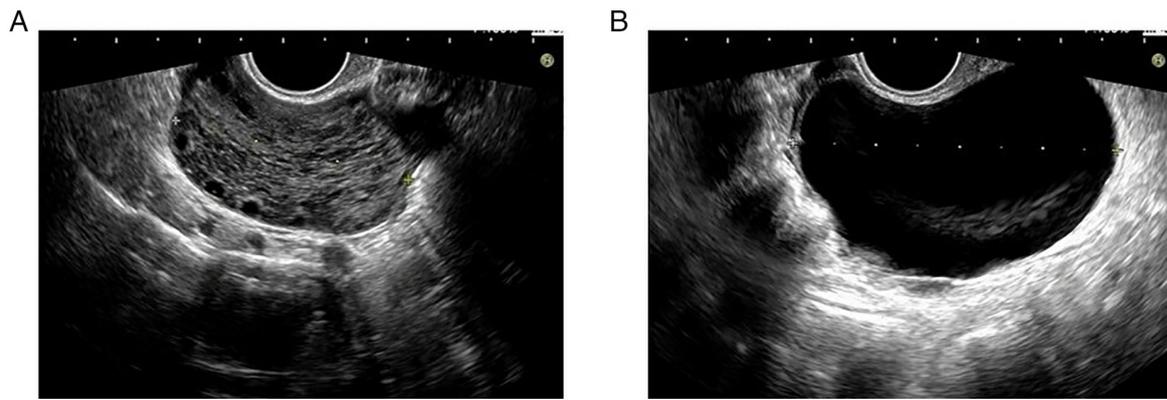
Pre-operative transvaginal ultrasonographic images. (A) A 57.7-mm solid lesion with multiple peripheral ovarian follicles and (B) a 77.9-mm cystic lesion were identified in the left adnexa.
